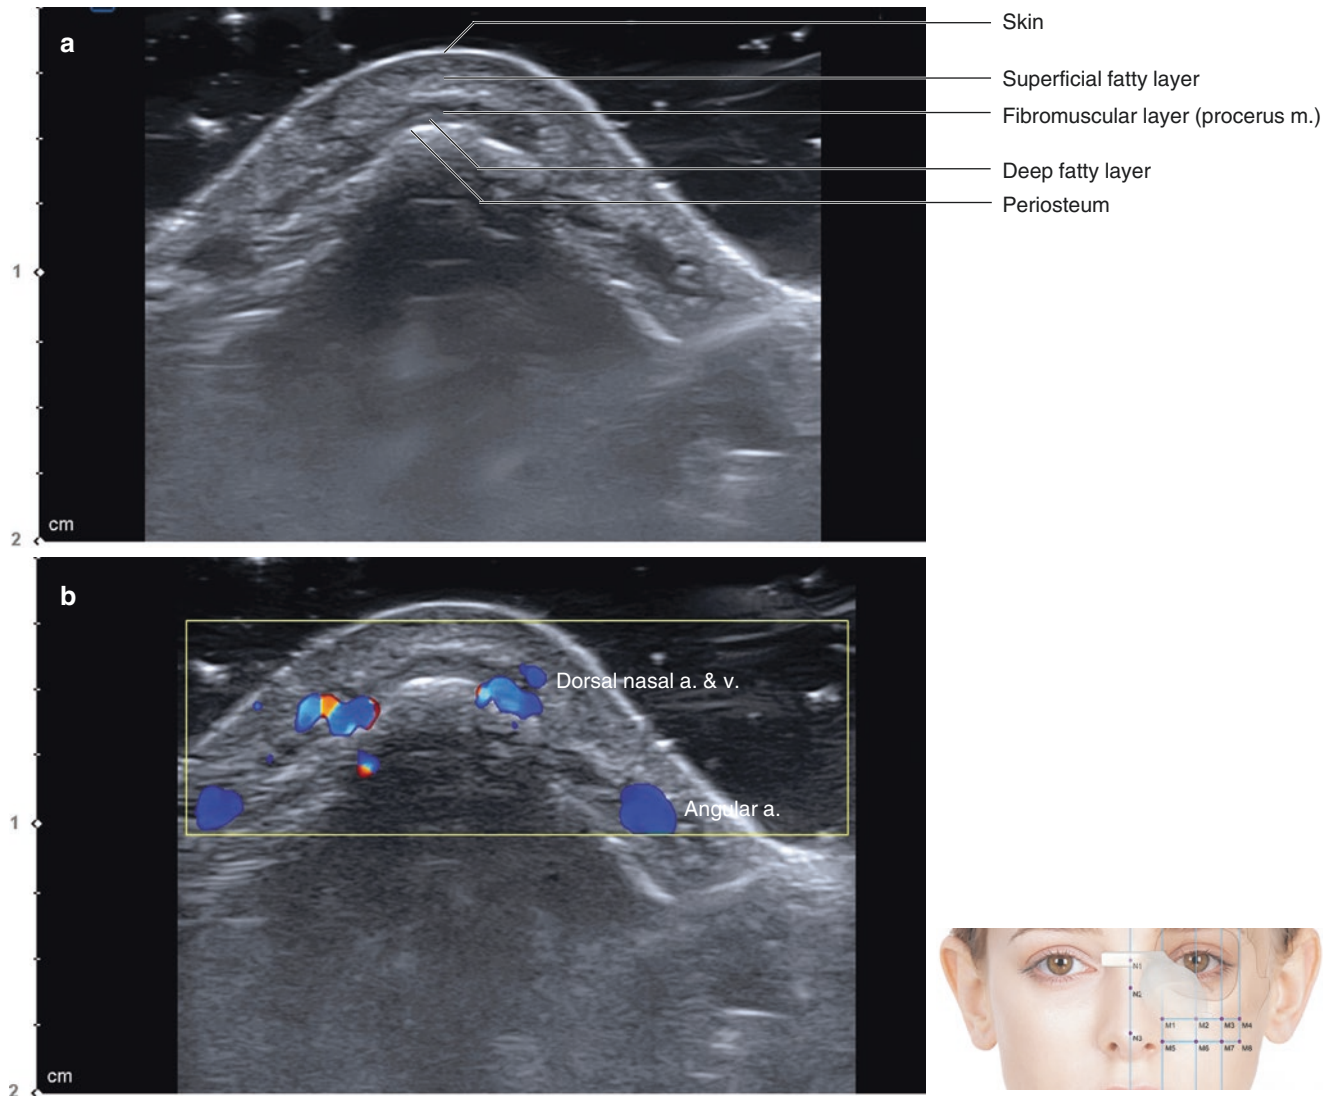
Ultrasonography of the sellion (N1). (a) B mode (transverse view, 15 MHz by linear transducer), (b) Doppler mode (transverse view, 15 MHz by linear transducer), and (c) Doppler mode (midsagittal view, 15 MHz by linear transducer). (Published with kind permission of © Hee-Jin Kim 2020. All Rights Reserved)
